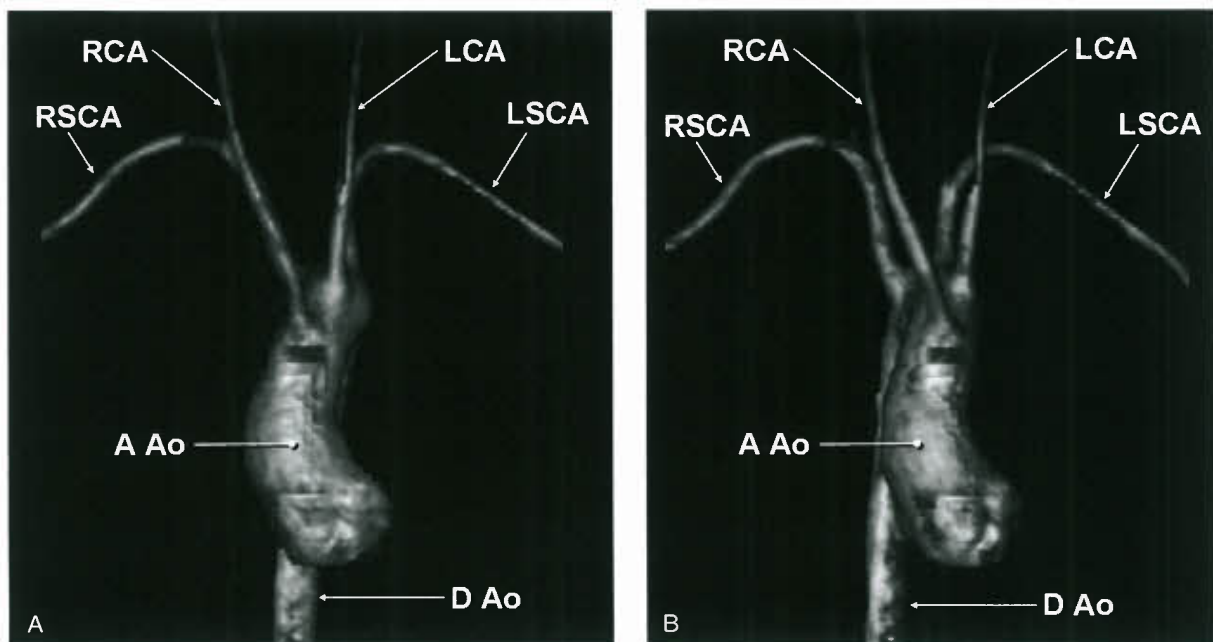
Left arch, retroesophageal right subclavian artery. A: Anterior view of 3-D shaded surface display from MRI. Note that RCA is superimposed on RSCA in this view. B: RCA and RSCA separated in slightly right anterior oblique view showing sequence of arch vessels: RCA, LCA, LSCA, and RSCA.
